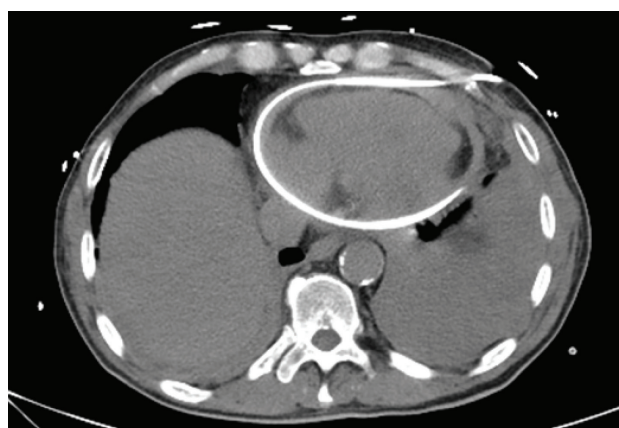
Chest CT scan after the pericardiocentesis.
